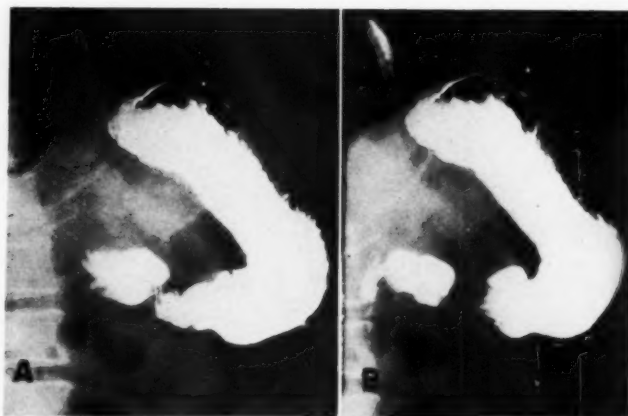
Normal stomach showing antral systole as described by Golden (4). Note criss-cross of folds in the first roentgenogram (A) and smooth straight folds in the second (B).
